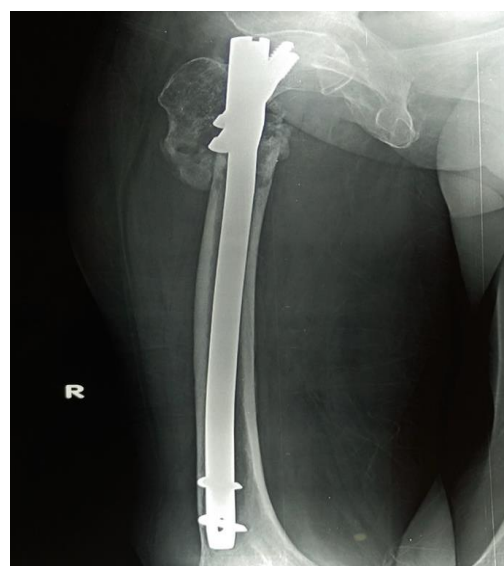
Post-operative radiograph of case 2 with Long PFN in situ
